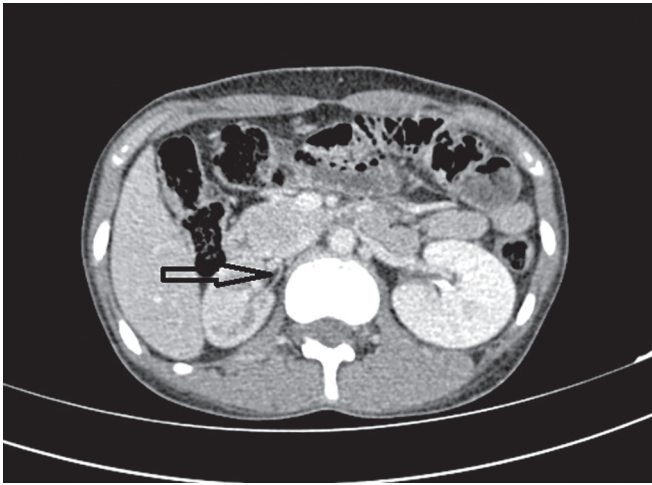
Contrast CT of abdomen shows small right kidney with thin right renal artery
